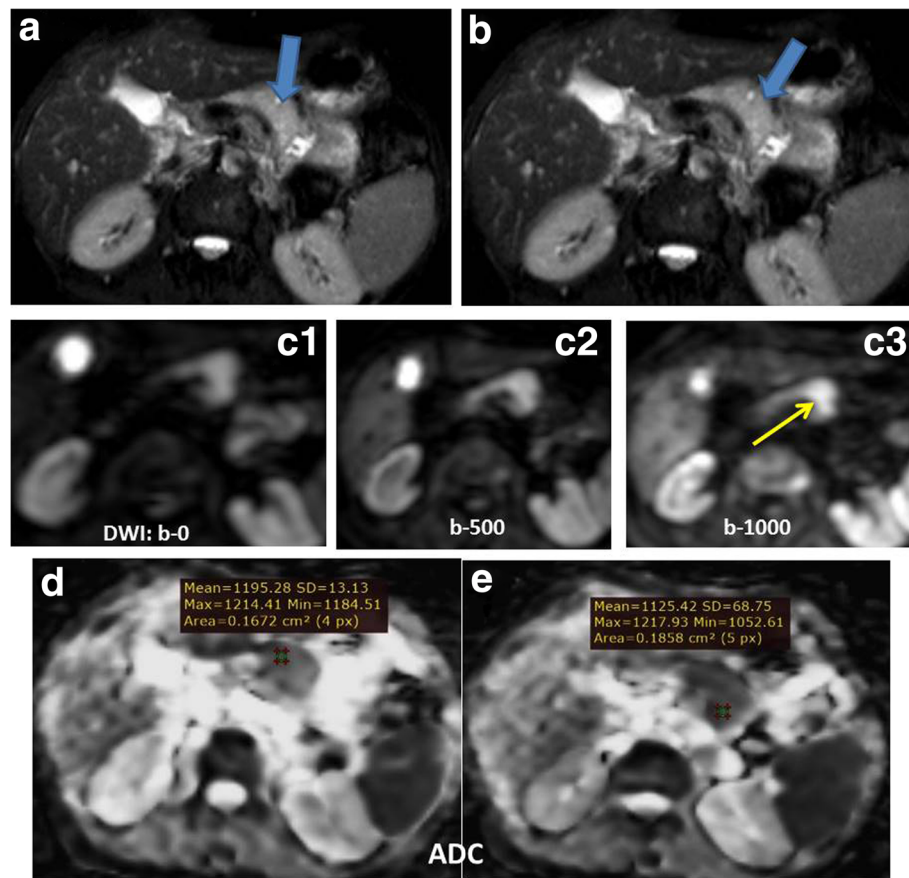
A 70-year-old male patient presented with abdominal discomfort and pain. a, b Axial T2 fat saturation revealed just deformed contour of pancreatic body with no detectable abnormal signal lesions. c1–c3 DWI at multiple b values (0, 500, and 1000 s/mm^2). The lesion appeared with increased restriction by elevating the b value (yellow arrow at c3). d, e The pancreatic lesion showed low signal at ADC map with low ADC value ($1.1 \times 10^{-3} \text{ mm}^2/\text{s}$). The lesion abuts the superior surface of the mesenteric vessels but not encase them (resectable lesion)
